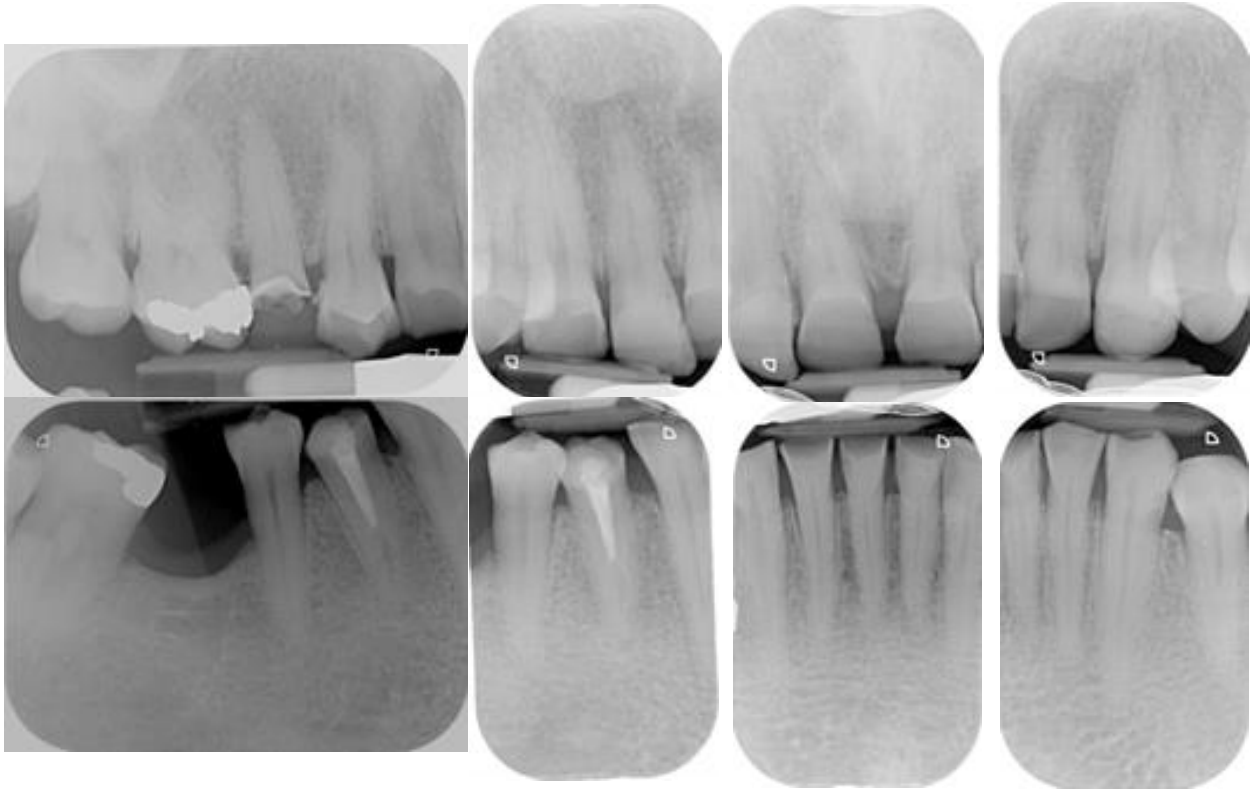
Periapical radiographs. Inadequate coronal tooth structure of tooth 15 can be seen with the cavity appearing to be near the pulp. Teeth 11 and 21 appear to have short roots. Root filling on tooth 44 appears to be insufficient in length of the obturation with periapical radiolucency.
